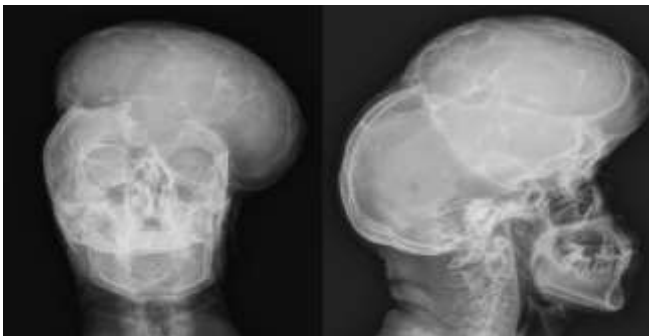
Skull Radiography: AP and Lateral views demonstrating extensive "punched-out" osteolytic lesions and massive destruction of the frontal and parietal bones
